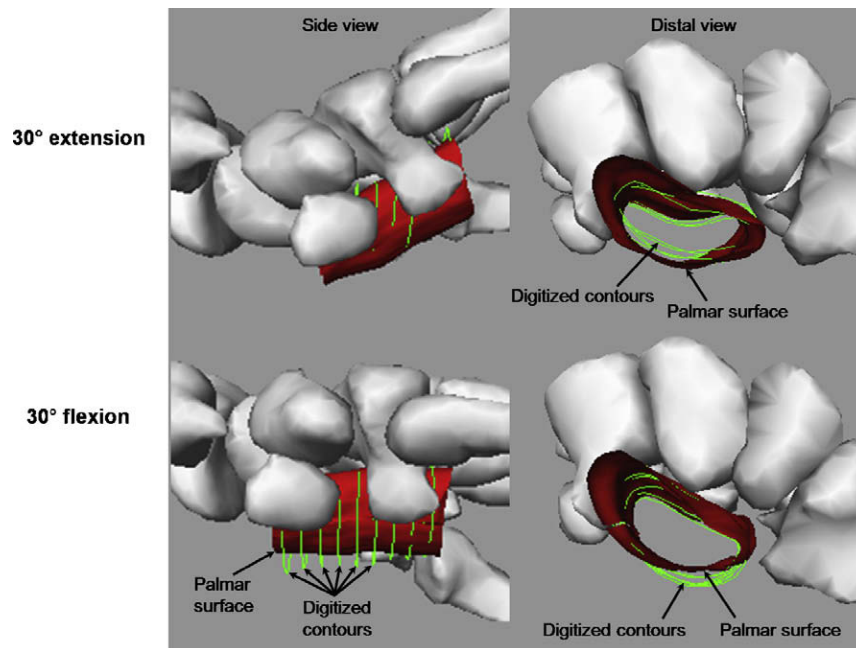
Comparison of carpal tunnel surfaces with the contours digitized from MRI reveals non-physiological “bellying” of the palmar surface in extension (top, i.e. ligament surface lies palmar to digitized contours), but lack of “bellying” in flexion (bottom, i.e. digitized contours lie palmar to ligament surface).
